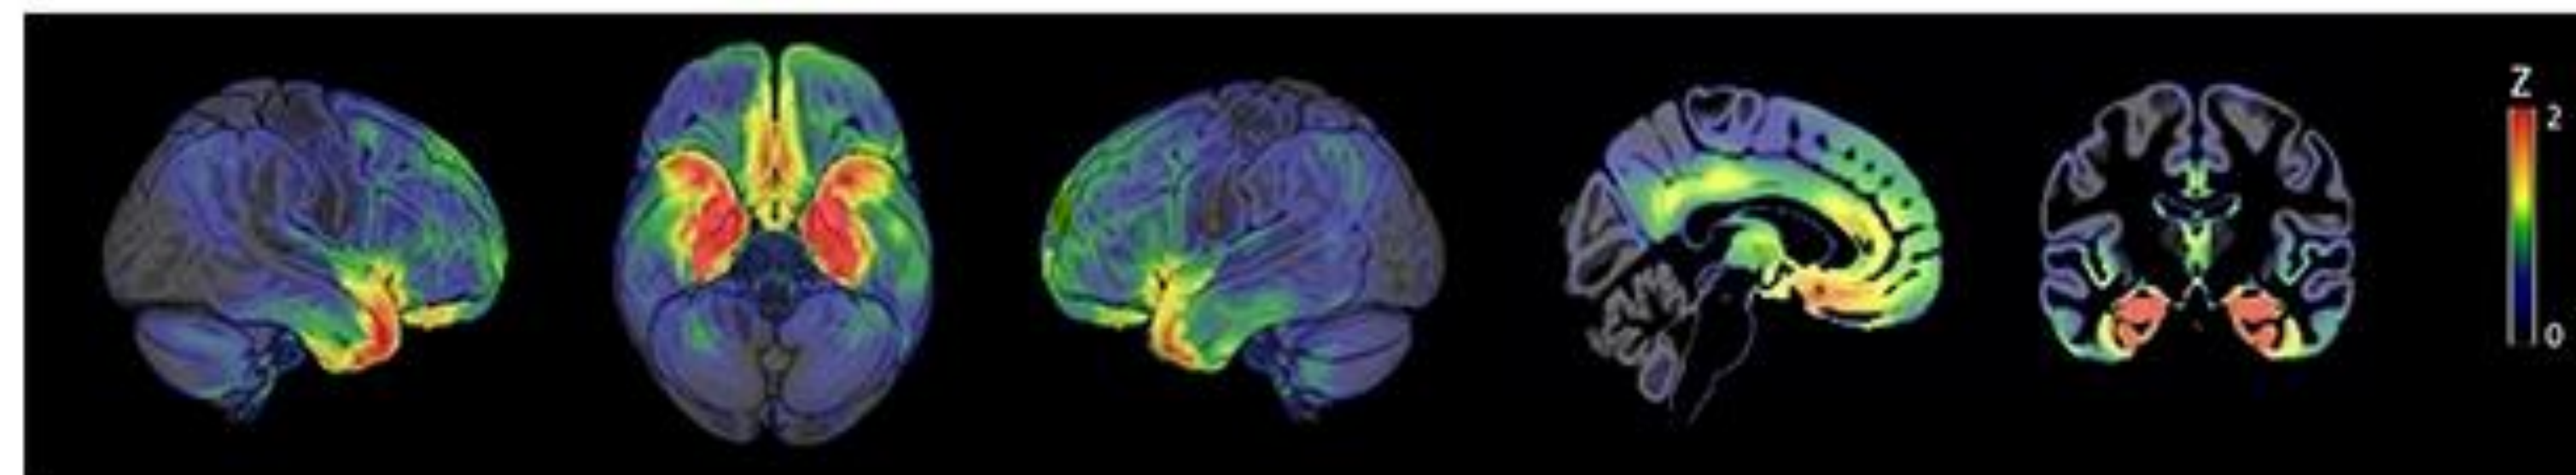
FDG-PET pattern of hypometabolism of LATE within the temporolimbic region of the brain³
